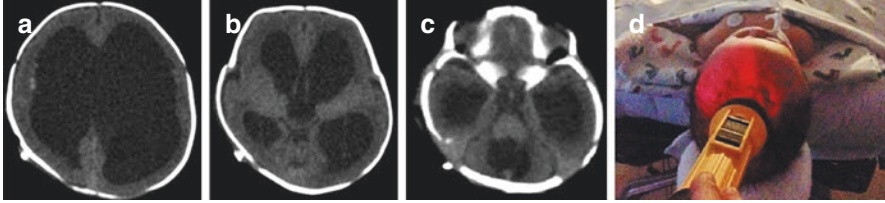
Transillumination sign. A 3-month-old baby, presenting with bulging fontanelle, sun-setting eyes, and vomiting. (a) Axial CT scan showing dilation of the lateral ventricles and thinning of the adjacent parenchyma. (b) Axial CT scan showing dilation of the III ventricle and transependymal exudate. (c) Axial CT scan demonstrating communicating hydrocephalus. (d) Transillumination sign, preoperatively for shunt placement
